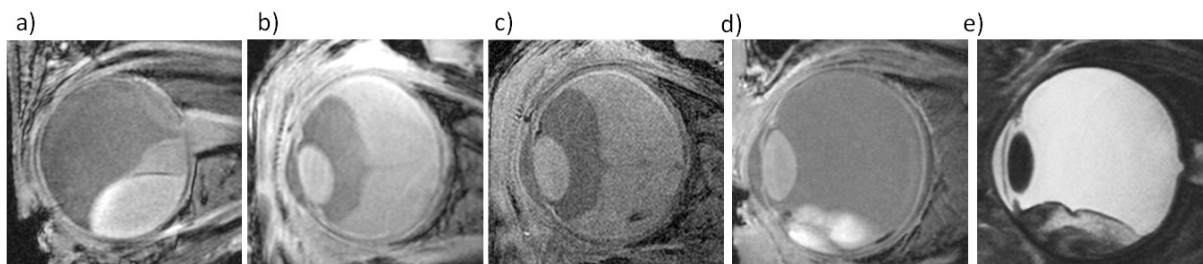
Results of ophthalmic MRI in healthy subjects using the six-channel transceiver array. (a) Transversal view of the eye derived from 3D GRE imaging using a spatial resolution of  $0.2 \times 0.2 \times 1.0 \text{ mm}^3$  and (b)  $0.3 \times 0.3 \times 1.0 \text{ mm}^3$ . (c) Sagittal views of the eye derived from 3D IR-GRE imaging using a spatial resolution of  $0.4 \times 0.4 \times 1.0 \text{ mm}^3$ . (d) Sagittal views of the eye derived from T2-weighted 2D FSE imaging with a spatial resolution of  $0.25 \times 0.25 \times 0.7 \text{ mm}^3$ .
